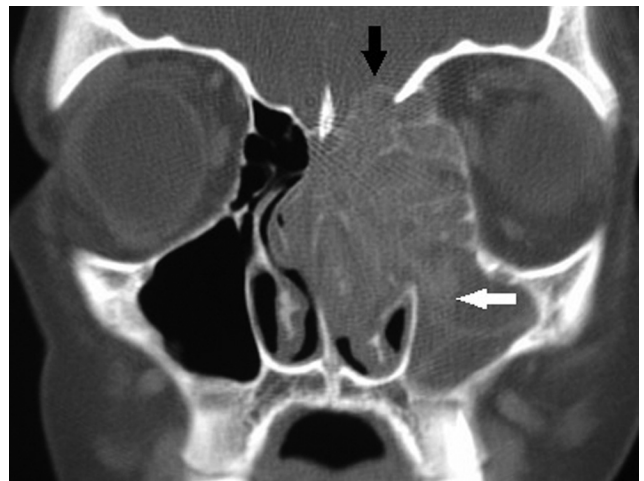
Coronal computed tomography (CT) scan of the paranasal sinuses with soft tissue windows showing unilateral opacification of the maxillary and ethmoid sinuses with bony erosion into the skull base (black arrow) as well as expansion into the left orbit. Note the characteristic hyperattenuated areas in the maxillary sinus suggestive of allergic fungal rhinosinusitis (AFRS; white arrow).
